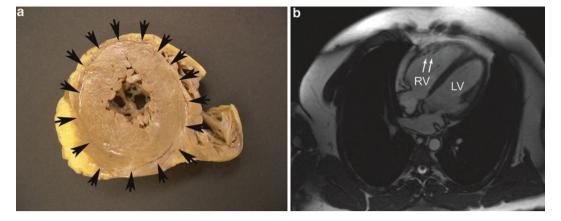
(a) Arrhythmogenic cardiomyopathy/ventricular cross-sectional slice containing circumferential subepicardial fibrofatty replacement of the left ventricular free walls and compact myocardium of the septum, characteristic gross finding of arrhythmogenic cardiomyopathy, left ventricular dominant form (*arrows* point to subepicardial and septal fibrofatty replacement). (b) Arrhythmogenic cardiomyopathy. Cardiac MRI. Axial views. Right ventricular (RV) enlargement. Fatty replacement (*arrows*) of cardiac muscle in RV wall
